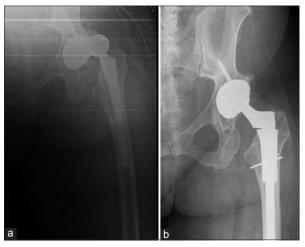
(a) X-ray pelvis anteroposterior view showing anterior dislocation of the left total hip arthroplasty at the early postoperative period (Case 5) (b) X-ray pelvis anteroposterior view at third- month visit (Case 5). Instability was managed by optimizing femoral version using a modular stem
